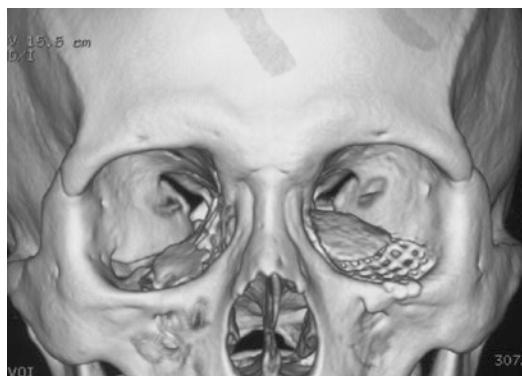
Postoperative CT showed that the titanium mesh was implanted into the left orbit, the orbital structure was restored, the titanium mesh and hydroxyapatite wedge-shaped fill which is soaked with iodized oil were in good position (*front view*)
